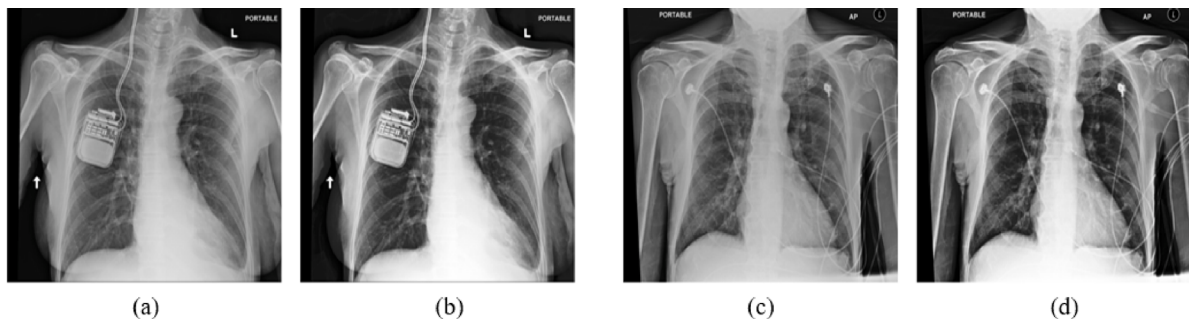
A sample of chest X-ray image: (a) and (c) original image, (b) and (d) sharpened image using the Histogram Equalization technique.
